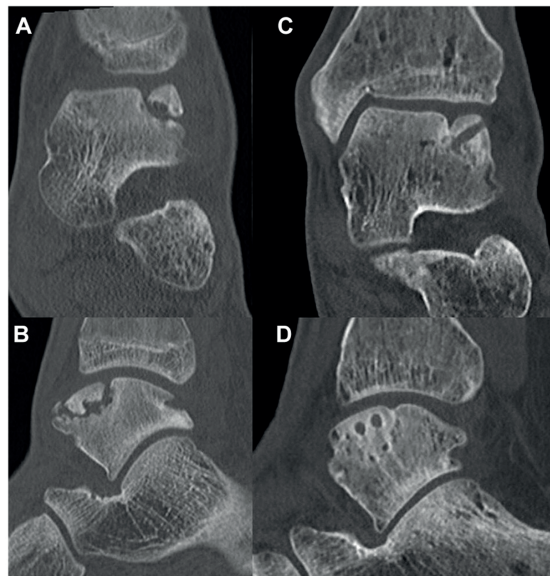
Pre-operative coronal (a) and sagittal (b) and 1-year postoperative (c and d) CT-scan images of a 16-year-old male with an anterolateral osteochondral fragment of the talus, who underwent open LDFF with two bioscrews. The postoperative radiolucencies on the talus are the bioscrew in-situ.
